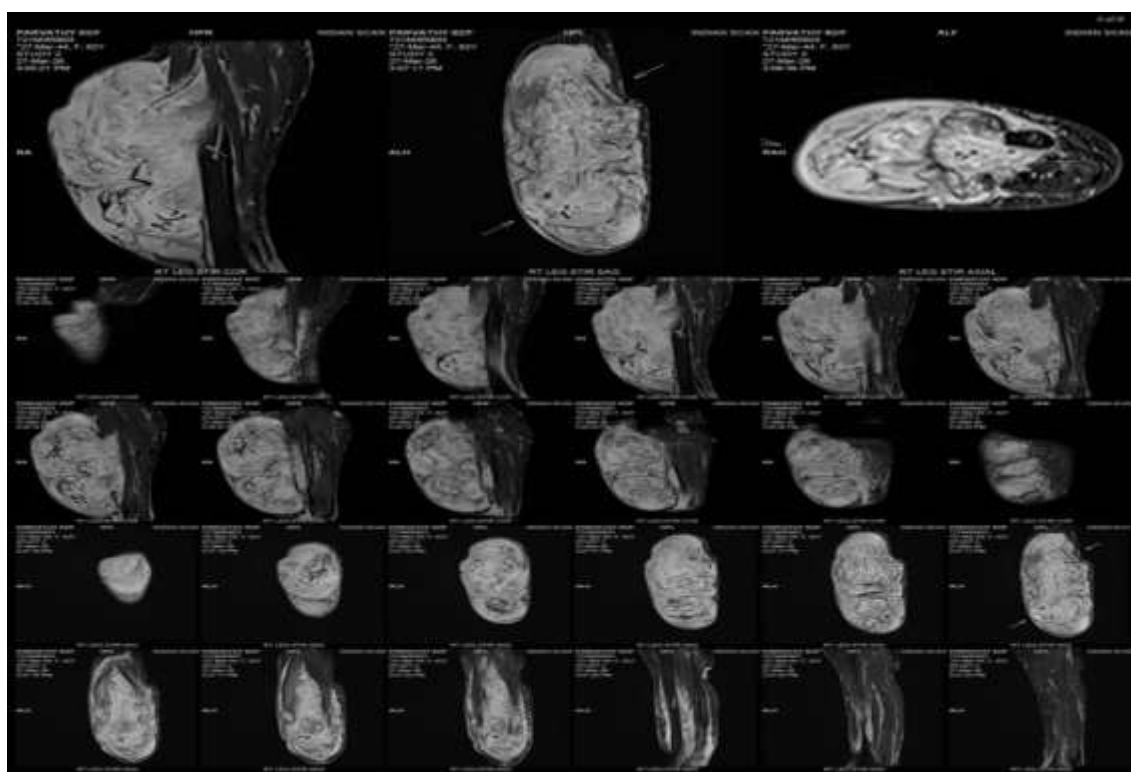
Magnetic resonance imaging (MRI) of the right leg demonstrating an ill-defined lobulated intramuscular lesion with subcutaneous extension in the anterior compartment, suggestive of plexiform neurofibroma, myxomatous lesion, or sarcomatous lesion.
